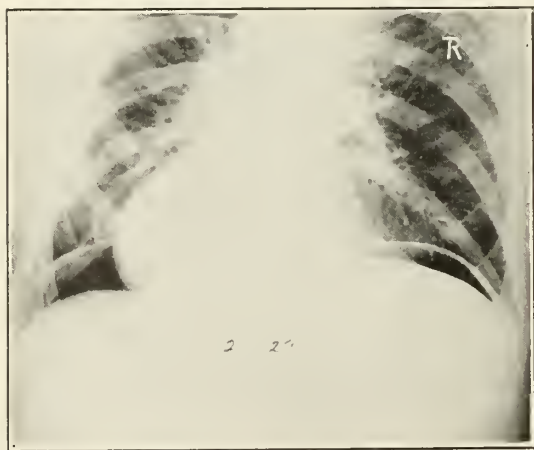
Moderate spontaneous pneumoperitoneum. Roentgen ray examination 4 hours after perforation. Operation 7 hours after perforation revealed perforated duodenal ulcer. Recovery. Characteristic sickle-shaped area of gas.
